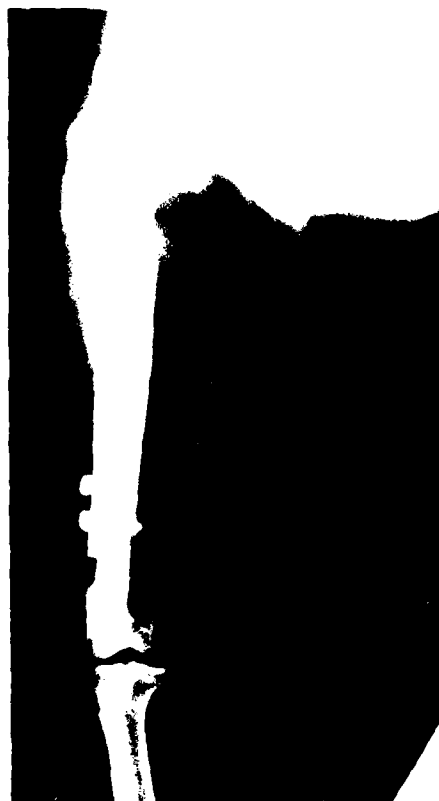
Fifteen-month post operative X-ray of femoral segmental replacement showing apparent reconstruction of entire diaphysis.
